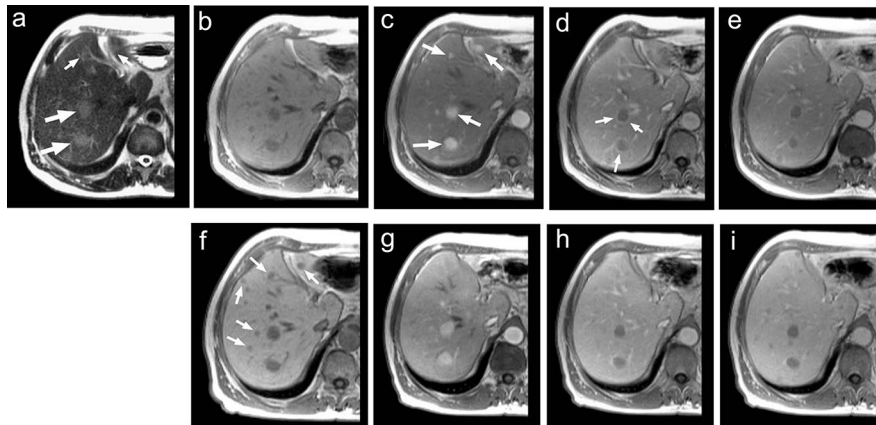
Multifocal HCC in a 58-year-old male patient. The unenhanced T2-weighted image (a) clearly reveals 2 focal areas (large arrows) of hyperintensity of approximately 2–3 cm diameter each in liver segments VII and VIII. Additional small areas of hyperintensity (small arrows) are also evident in segment IV and elsewhere. On the corresponding unenhanced T1-weighted image (b), these lesions are markedly hypointense against the surrounding normal parenchyma. During the arterial phase at 25 seconds after the first injection of gadobenate dimeglumine at 0.05 mmol/kg bodyweight (c), the lesions appear strongly hyperintense (arrows). However, the contrast has washed out completely by the portal-venous phase at 60 seconds (d), leaving the lesions as markedly hypointense with characteristic hyperintense peripheral rims (small arrows). This pattern of enhancement persists into the equilibrium phase at 5 minutes after injection (e). On the delayed phase image (f), the lesions are still strongly hypointense against the enhanced normal parenchyma although the peripheral rims can no longer be seen. Numerous small lesions (small arrows) identified as focal areas of hyperintensity during the arterial phase are clearly seen as hypointense during the delayed phase. A similar pattern of enhancement to that seen during the first dynamic series is seen during a second dynamic series (g, h, and i) acquired after a second injection of 0.05 mmol/kg gadobenate dimeglumine.
